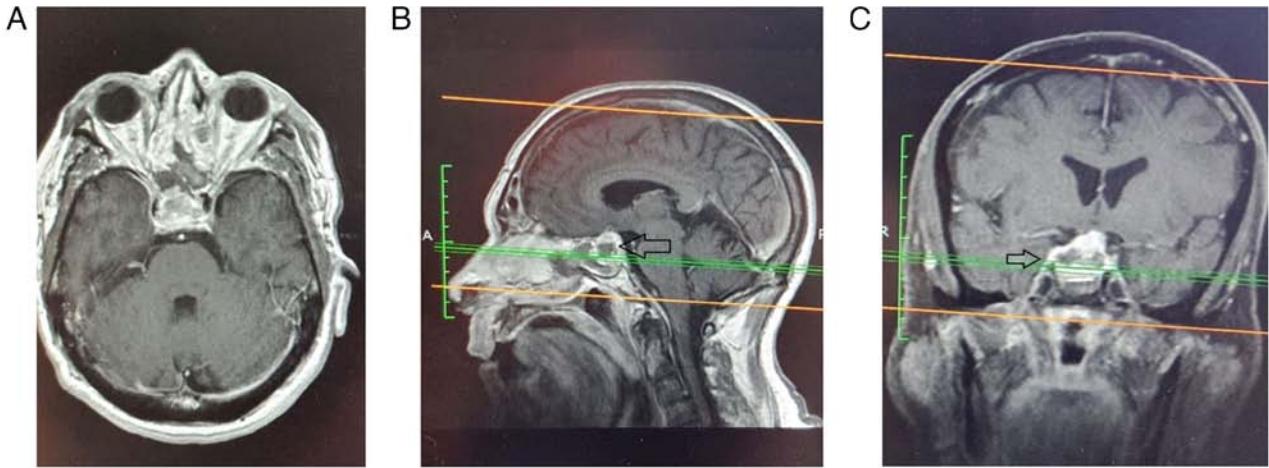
(A-C) Pre-operative contrast enhanced T1 MRI scan of patient 5, with pituitary apoplexy (arrows) due to a pituitary macroadenoma.
